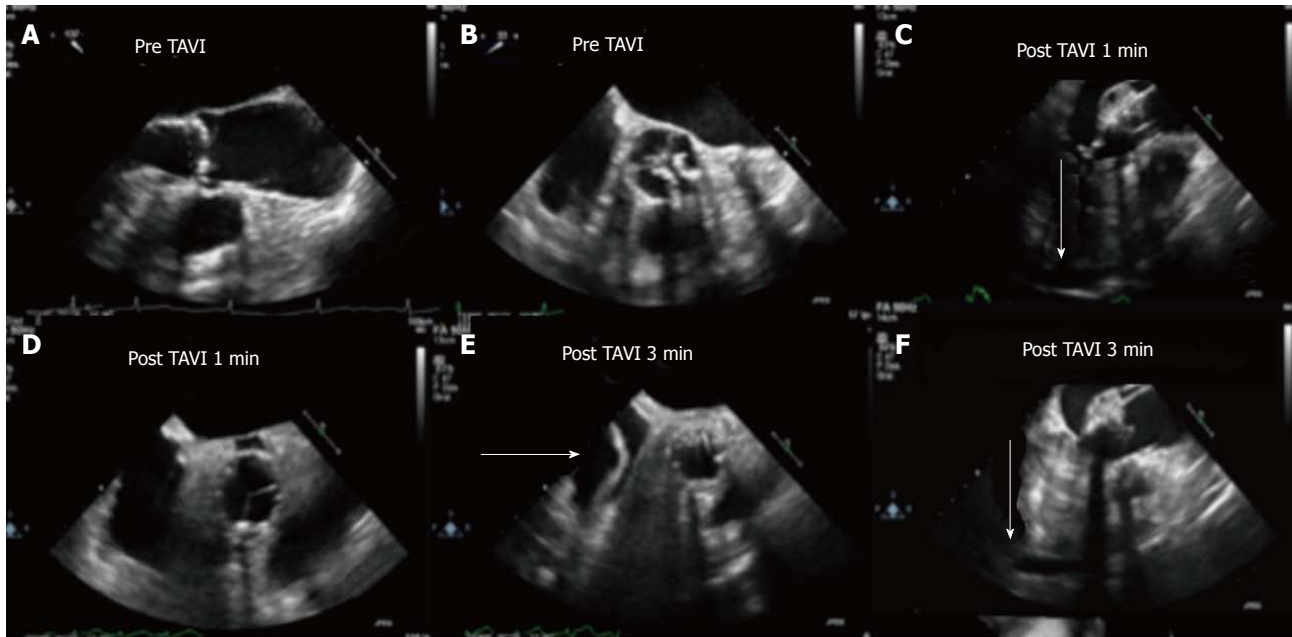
Aortic root rupture and aortic root hematoma (Case 1). A and B: Aortic valve assessment before TAVI, TEE mid esophageal long axis view (A) and short axis view (B); C and D: Aortic valve assessment post TAVI 1 min; E and F: Aortic valve assessment post-TAVI 3 min. We can observe the development of the aortic root hematoma and the pericardial effusion (arrowhead). TAVI: Transcatheter aortic valve implantation; TEE: Trans-esophageal echocardiography.
